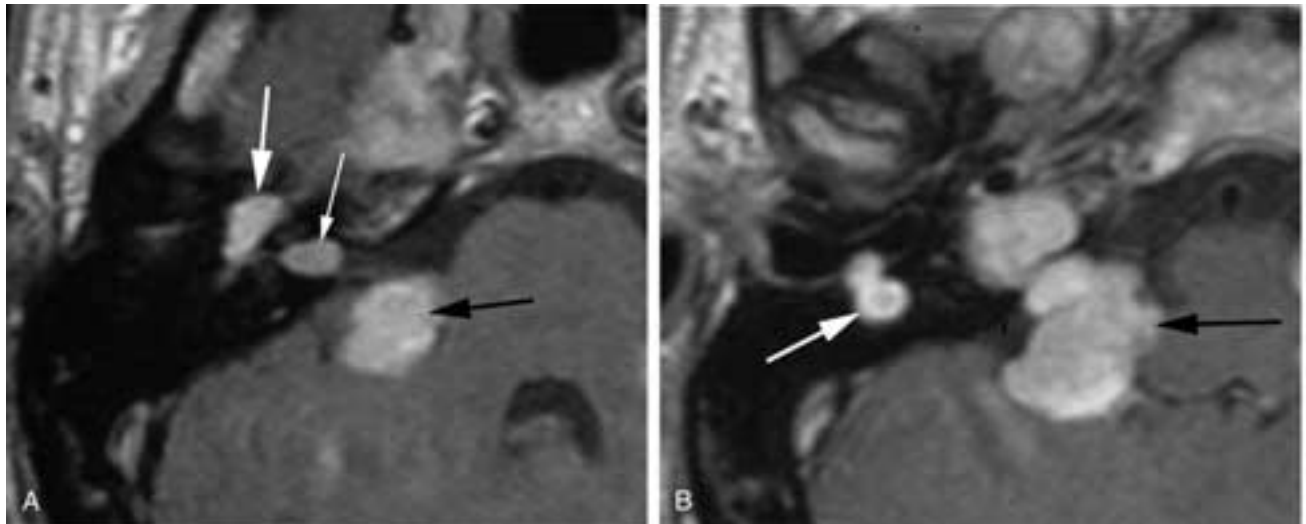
Patient with neurofibromatosis and multiple peripheral nerve tumors. A, T1-weighted postgadolinium axial MR image. There is involvement of the IAC (*small white arrow*) and the geniculate turn/anterior tympanic segment (*large white arrow*) of the FNC. The enhancement (*black arrow*) in the posterior fossa is the upper edge of a tumor extending through the jugular foramen. B, Coronal MR image shows the enlarging lesion in the vertical (mastoid) FNC (*white arrow*). Note the small protuberance of tumor just anterior to the vertical FNC. This tumor is following the chorda tympani nerve. Jugular foramen tumor (*black arrow*). (Courtesy of Dr. H.D. Curtin.)
